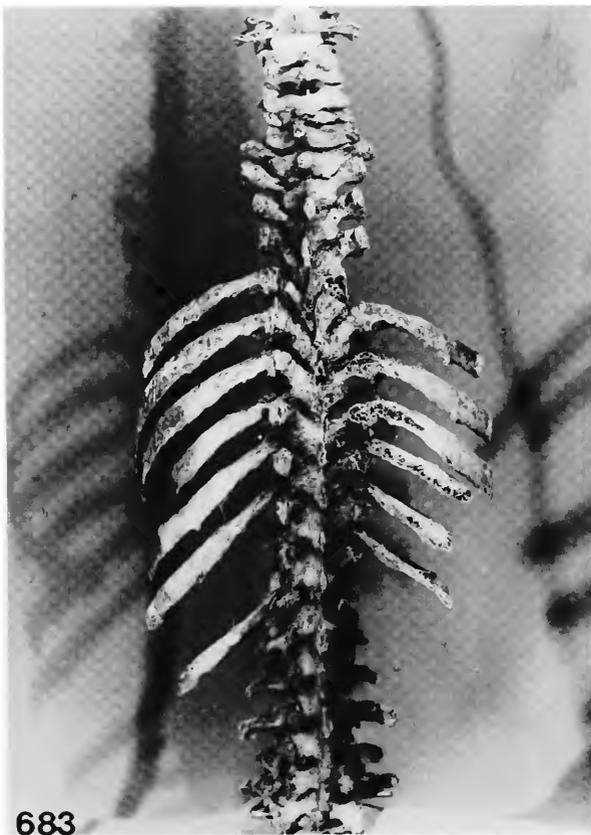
Ankylosing spondylitis of spine: 681, Anterior view of spine. 682, X-ray of anteroposterior view of fused vertebrae and ribs. (Adult male skeleton from Kuskokwim River, Alaska, USA, NMNH 351296.)
